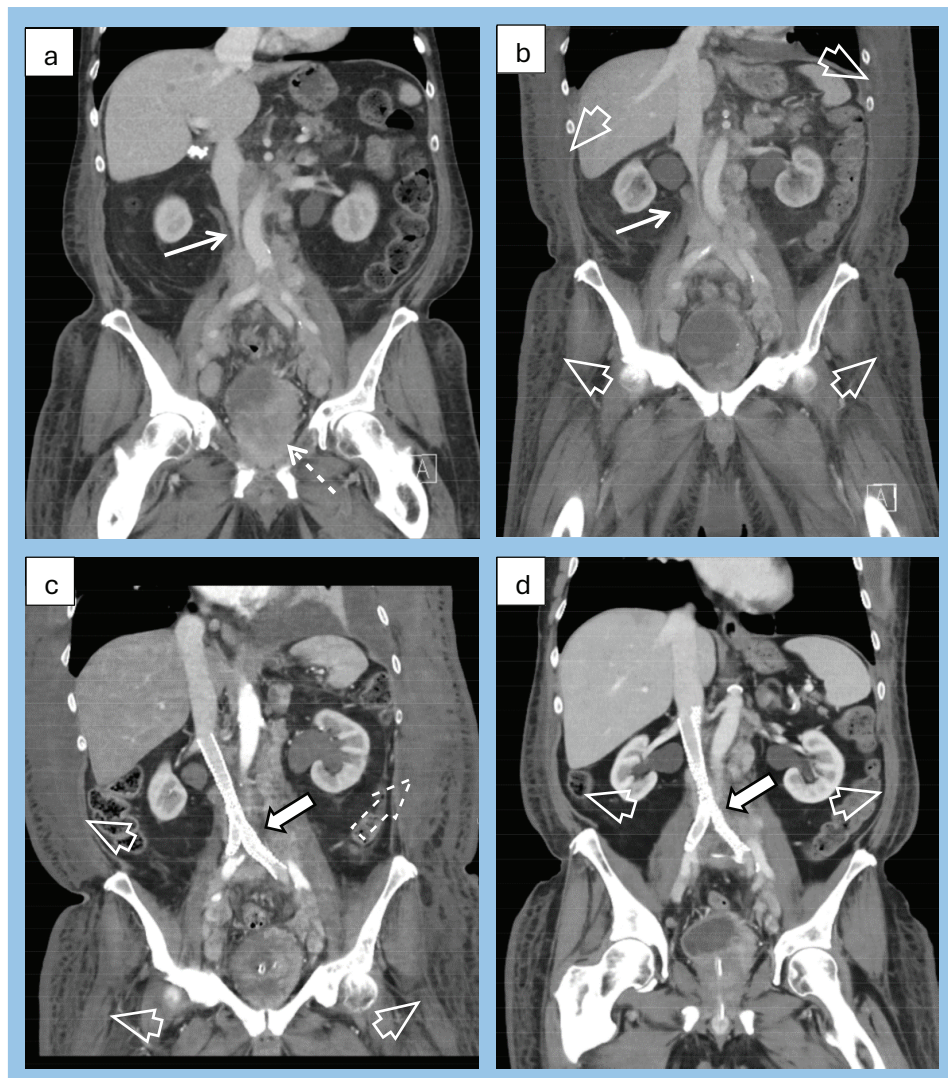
CT coronal views of the IVC throughout the course of events from diagnosis (a) up to 2-months follow-up after intervention (d). (a) First CT of the patient showing the narrowing of the IVC (white arrow), confirming the diagnosis. Visible tumour in the bladder and prostate of the patient (interrupted line arrow). (b) One-month follow-up CT after diagnosis, when the patient experienced worsening of the symptoms and was admitted to the hospital. Radiologically visible worsening of the narrowing (white arrow) and the subcutaneous oedema (open arrow). (c) First CT after stent-intervention, which was performed acutely due to hemodynamic instability. Visible intravascular stent in the IVC and common iliac veins (white arrow), hematoma in the left abdominal wall (interrupted line arrow) and subcutaneous oedema (open arrows). (d) Two-months follow-up after stent intervention. Visible intravascular stent in the IVC and common iliac veins (white arrow) and significantly decreased subcutaneous oedema (open arrows).
